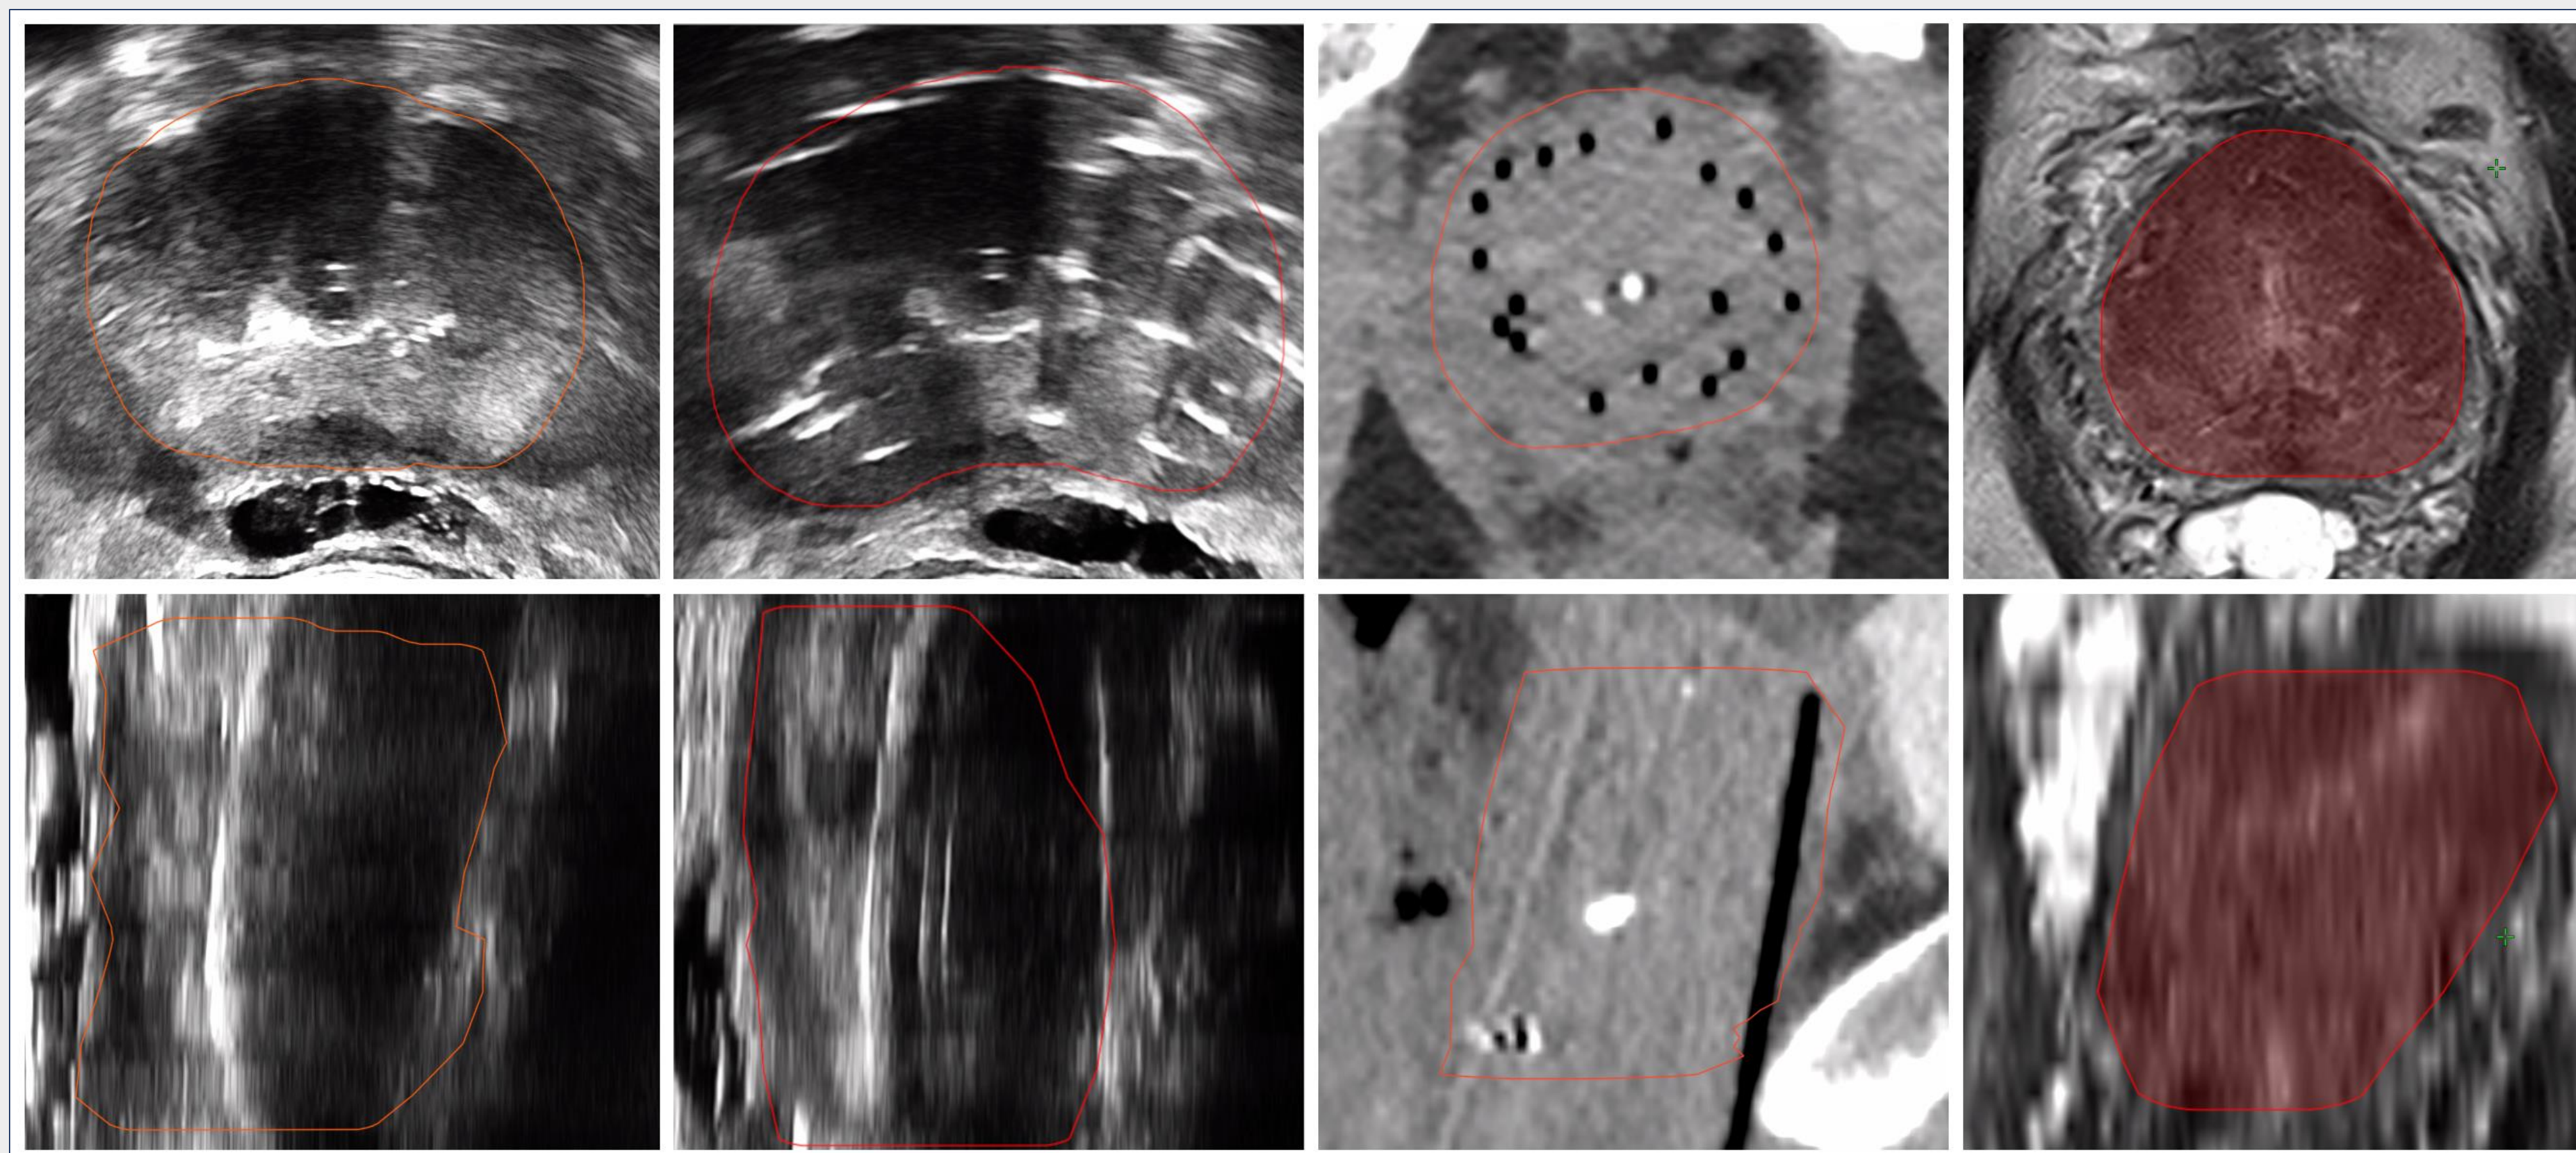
An example of all image types included in this study for Patient 10. From left to right: pre-needle insertion US, post-needle insertion US, post-needle insertion CT, post-HDR MRI with axial images on the top and sagittal images on the bottom.
